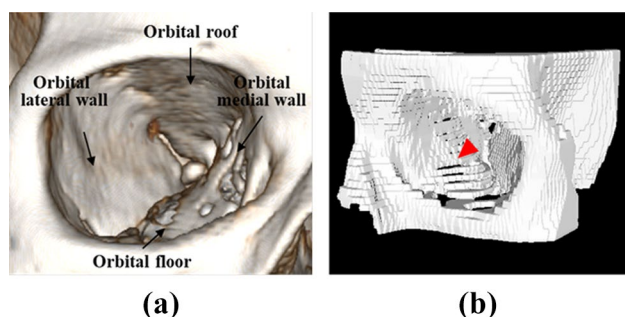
Characteristics of the orbital bone: a structure of orbit, b 3D-reconstructed model of the orbital bone from CT images with a thick slice thickness. The red arrow indicates the disconnection of the orbital floor
